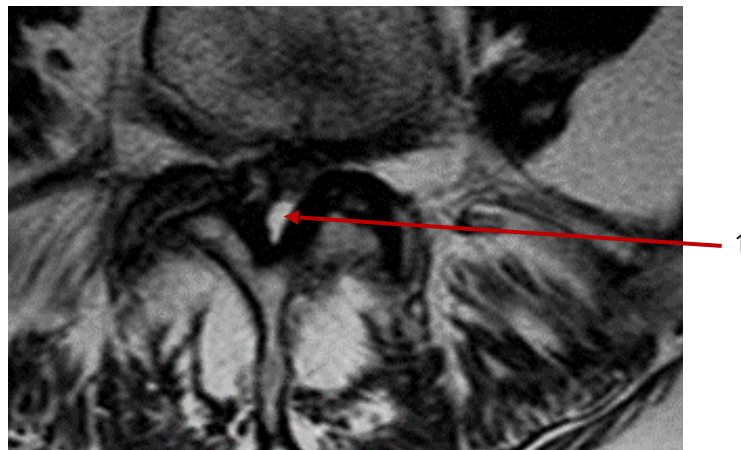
Magnetic resonance imaging (MRI):(1) facet joint cyst after treatment, after 4 months, on 24/10/2024
